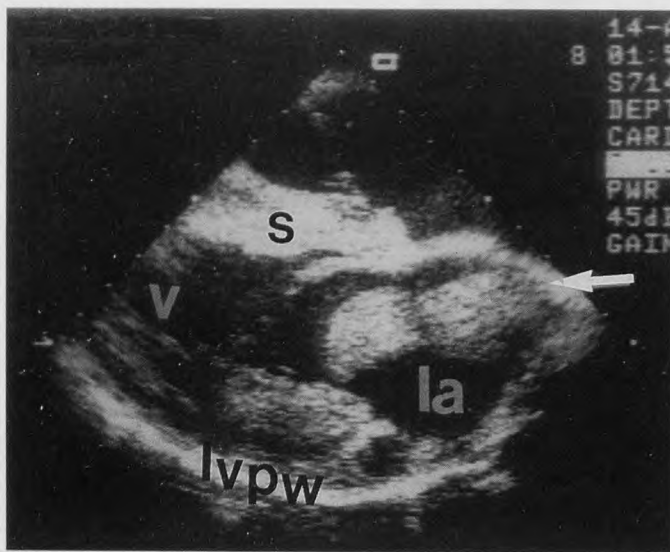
The long-axis view of the echocardiogram reveals the mass, designated by the arrow, within the left atrium; la denotes left atrium; v, left ventricle; lvpw, left ventricular posterior wall; s, septum.
